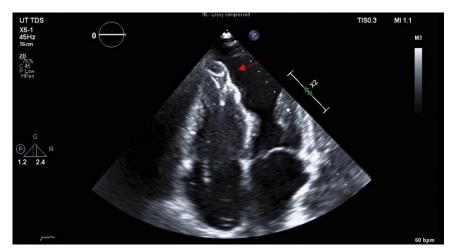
Apical four-chamber view showing closure of the VSD using an atrial septal defect occluder (arrow).
